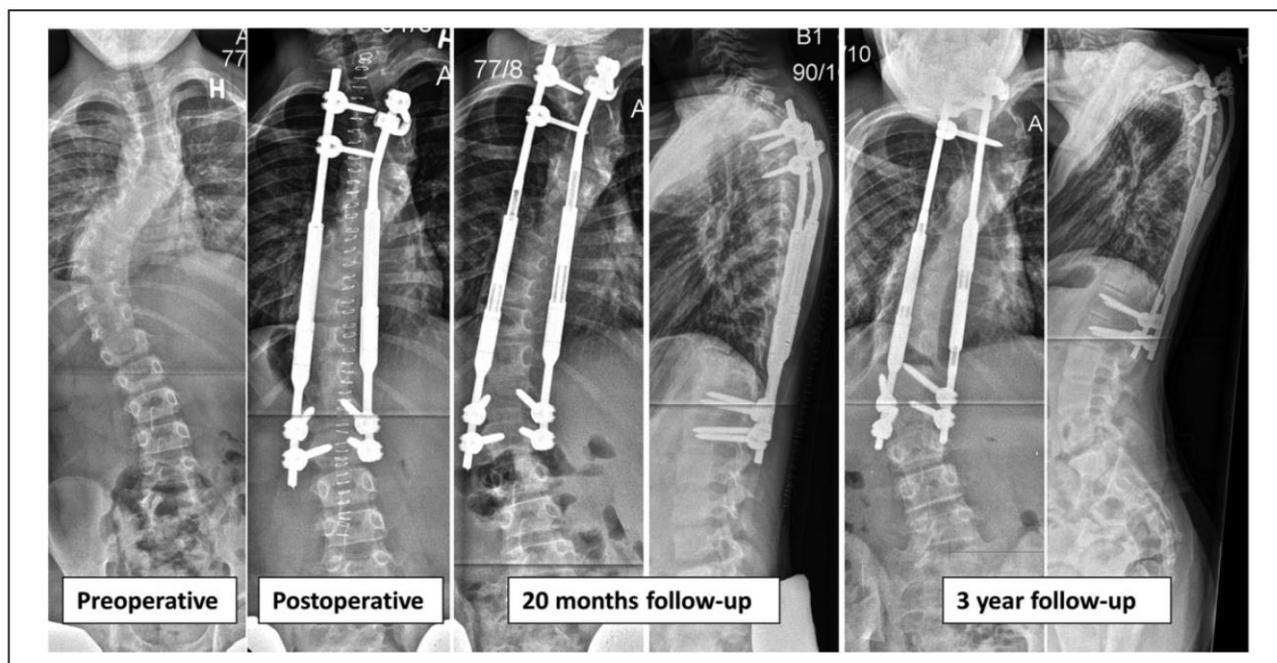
A case showing a 9-year old boy with neurofibromatosis type I. Progression despite Boston bracing. Preoperative major curve of 72° was reduced to 42° postoperatively. At 1-year follow-up, a CT scan showed proximal screw loosening on the right rod, but symptoms disappeared, and distractions were continued until full distraction at 20-month follow-up. After replacement of the rods, the patient developed proximal junctional kyphosis and hook displacement, and final fusion was performed 3 years after initial implantation. CT: computed tomography.
